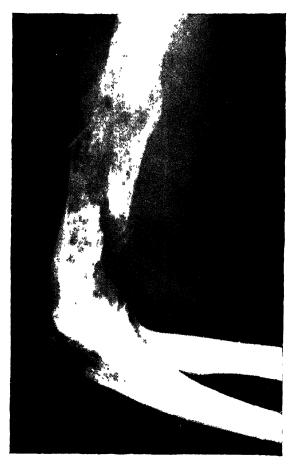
Roentgenogram of humerus. (Parker and Jackson. Surg., Gynec & Obst.)
